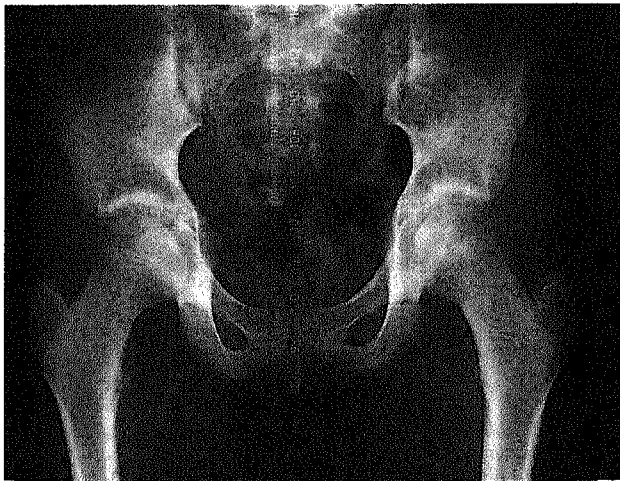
An anterior-posterior pelvic radiograph of a healthy 13-year-old boy without any signs of hip pathology. The peak shear stress in the epiphyseal growth plate equals 0.40 MPa for the right hip and 0.50 MPa for the left hip. The indication for radiograph was estimation of the leg length discrepancy that later (at skeletal maturity) turned out to be clinically insignificant.
